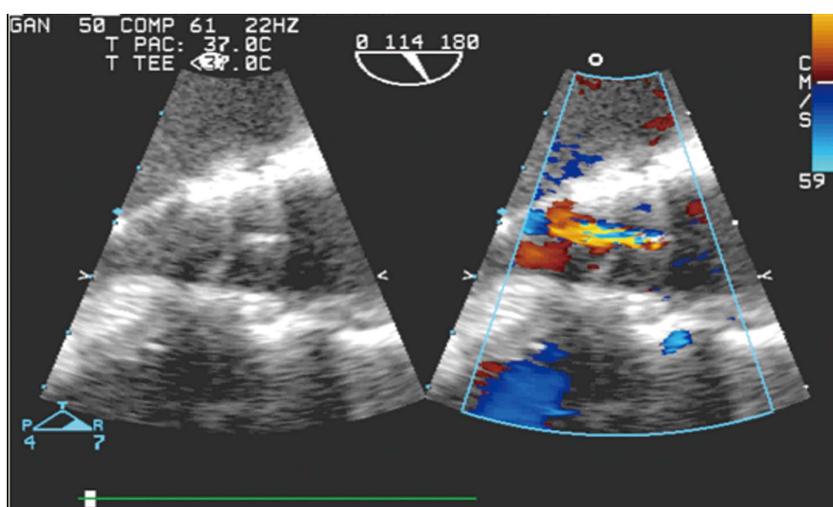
Transesophageal echocardiography at 114° without and with color Doppler depicting the presence of central aortic regurgitation due to underexpansion of the prosthesis.
